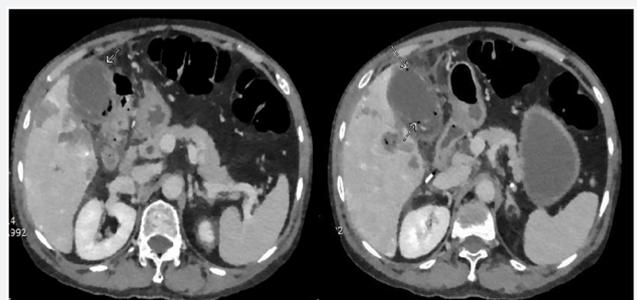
CT of the abdomen and pelvis revealing gallbladder wall edema (arrow head) and evidence of micro perforations with air in the gallbladder wall (arrows). Also noted are wedge-shaped areas of hypoattenuation in the liver compatible with post TACE changes.
